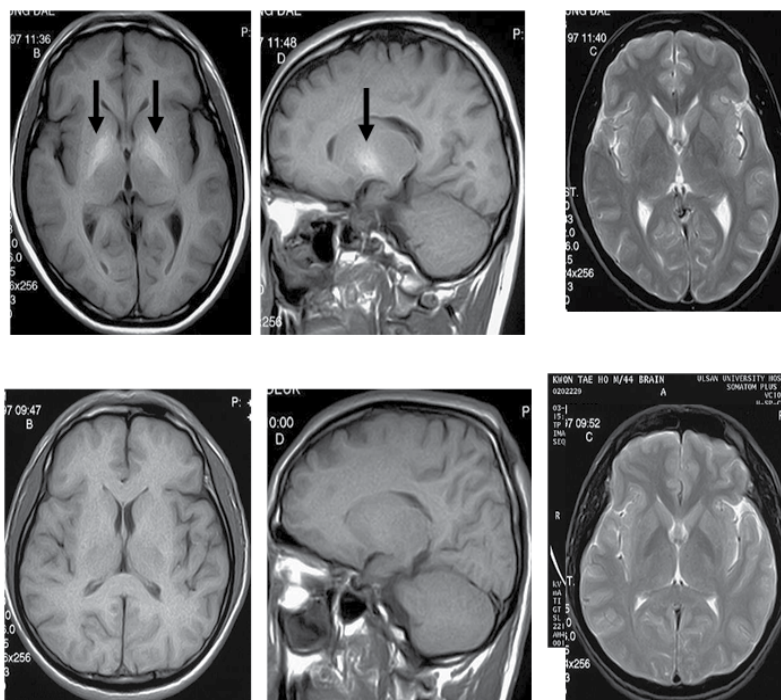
T1-weighted MRI scans with or without increased signal intensities. Axial and sagittal sections show increase in signal intensities mainly confined to the globus pallidus, but with no concomitant alteration on T2-weighted image in workers exposed to manganese (Mn) in the upper row. In the lower row, worker without Mn exposure does not show increased signal intensities (Arrow indicates high signal. Left and middle column: T1-weighted image; right column: T2-weighted image).
